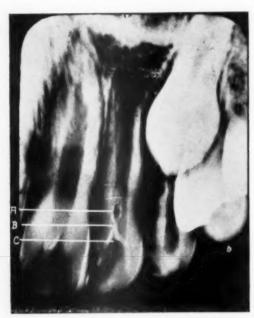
Radiograph of permanent maxillary lateral incisor disclosing C, lingual pit; B, constriction; A, internal cavity.
